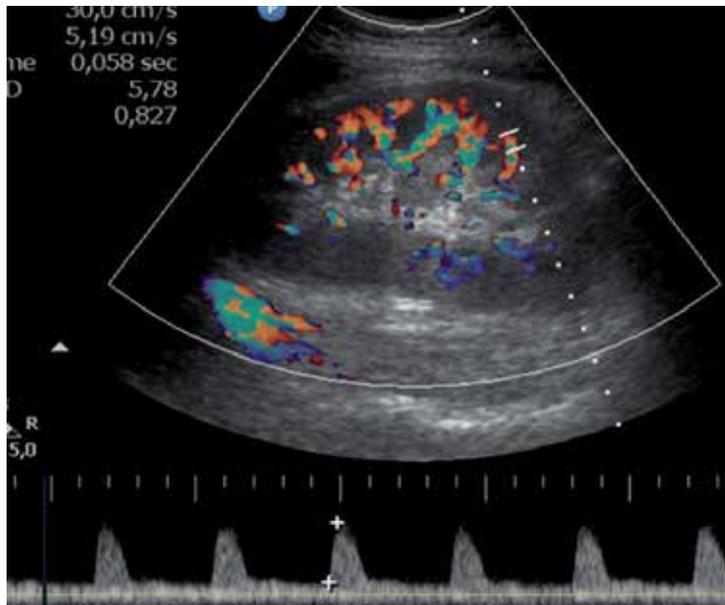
CNI toxicity. Spectral doppler evaluation with a mild elevation of RI.
